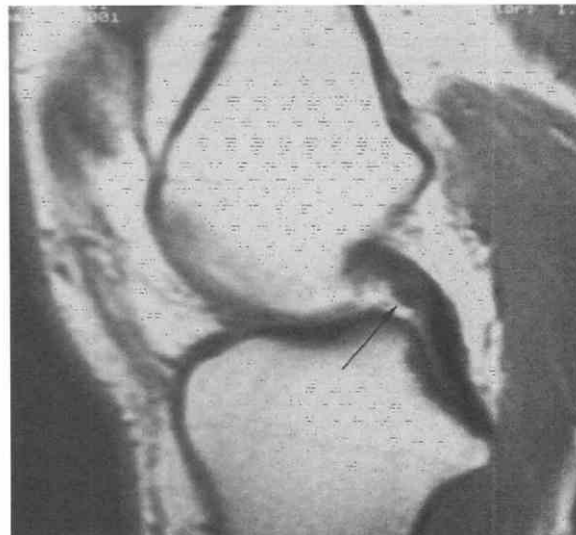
Normal posterior cruciate ligament (PCL) with the ligament of Humphrey. Sagittal T1-weighted image shows the normal course of the PCL. The anterior low-signal-intensity “dot” represents the ligament of Humphrey in cross-section (arrow).
